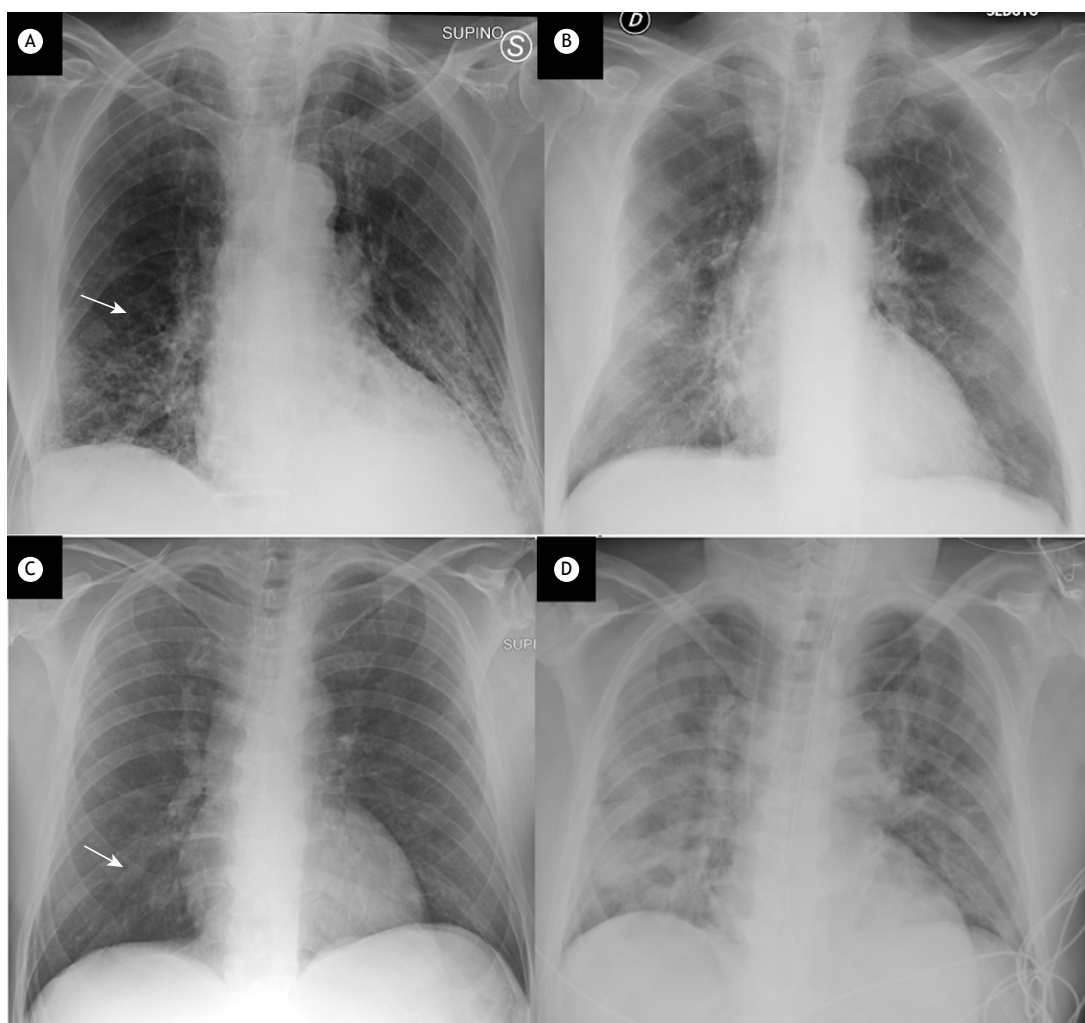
In A and B, chest X-rays of a 72-year-old male patient. In A, the chest X-ray was scored 2 due to right perihilar opacities (arrow). The patient presented with a $\text{PaO}_2/\text{FiO}_2$ ratio = 86 and CRP = 58 mg/L at admission to the ER; NIV was required. In B, a follow-up chest X-ray seven days later was scored 2 again (bilateral opacities). In C and D, chest X-rays of a 62-year-old male patient. In C, the chest X-ray was scored 1 due to unilateral opacity (arrow). The patient presented with a $\text{PaO}_2/\text{FiO}_2$ ratio = 103 and CRP = 165 mg/L at the onset of symptoms. In D, a chest X-ray performed two days later was scored 4 due to the presence of bilateral and diffuse opacities. The patient was referred to the ICU and intubated.
